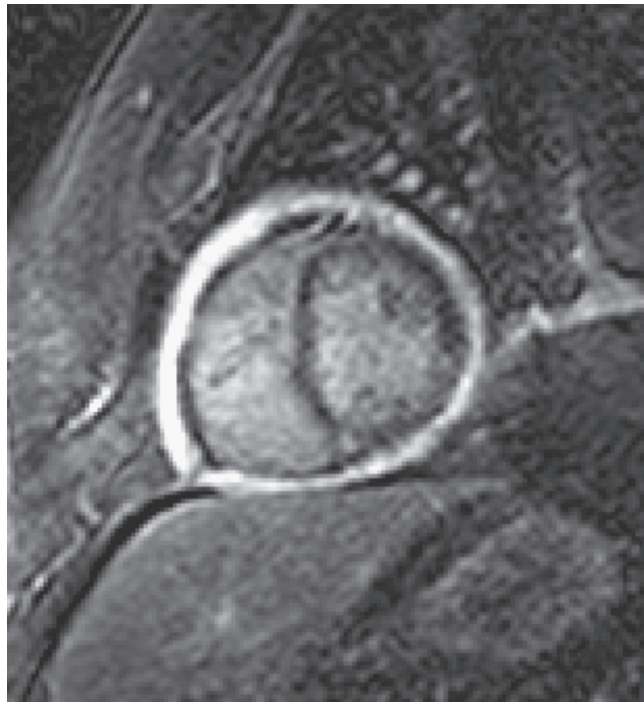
■ Pericarditis. Late gadolinium-enhancement cardiovascular magnetic resonance image in the short-axis view at the level of the mid-ventricle shows circumferential enhancement of the pericardium.
